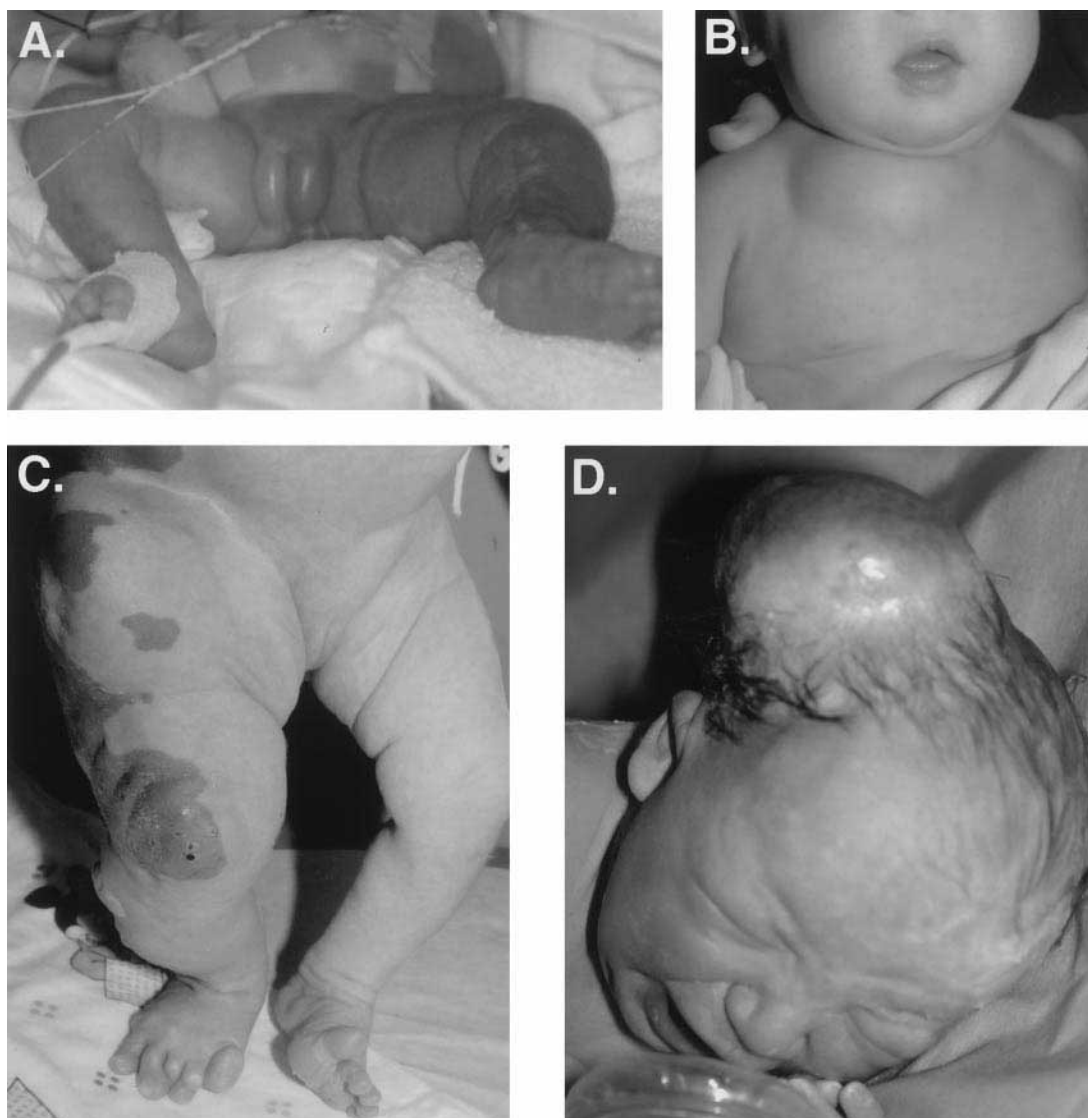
Examples of patients with prenatally diagnosed vascular anomalies. (A) Diffuse AVM of lower extremity and perineum of infant noted to be hydropic on antenatal sonogram (Parkes Weber syndrome). This infant died of complications of congestive heart failure. (B) Anterior cervical lymphatic malformation. (C) Capillary lymphatico-venous malformation of right lower extremity (Klippel-Trenaunay syndrome). (D) Congenital occipital hemangioma; this regressed rapidly.
